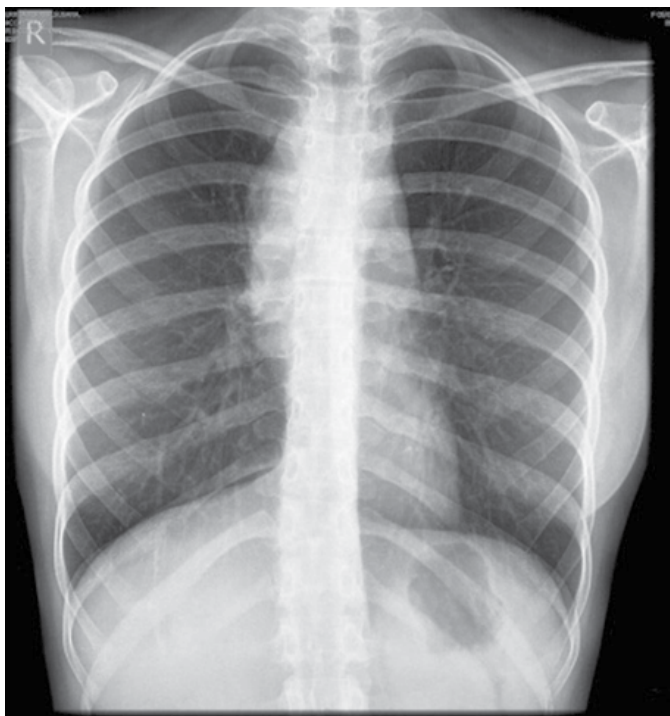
Chest X-ray after three cycles of chemotherapy.
